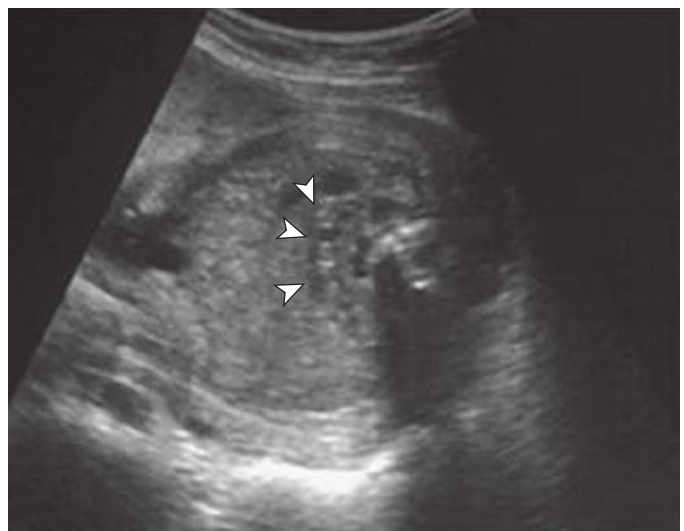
Horseshoe kidney. Demonstration of the isthmus is the most reliable sonographic clue to the diagnosis.
